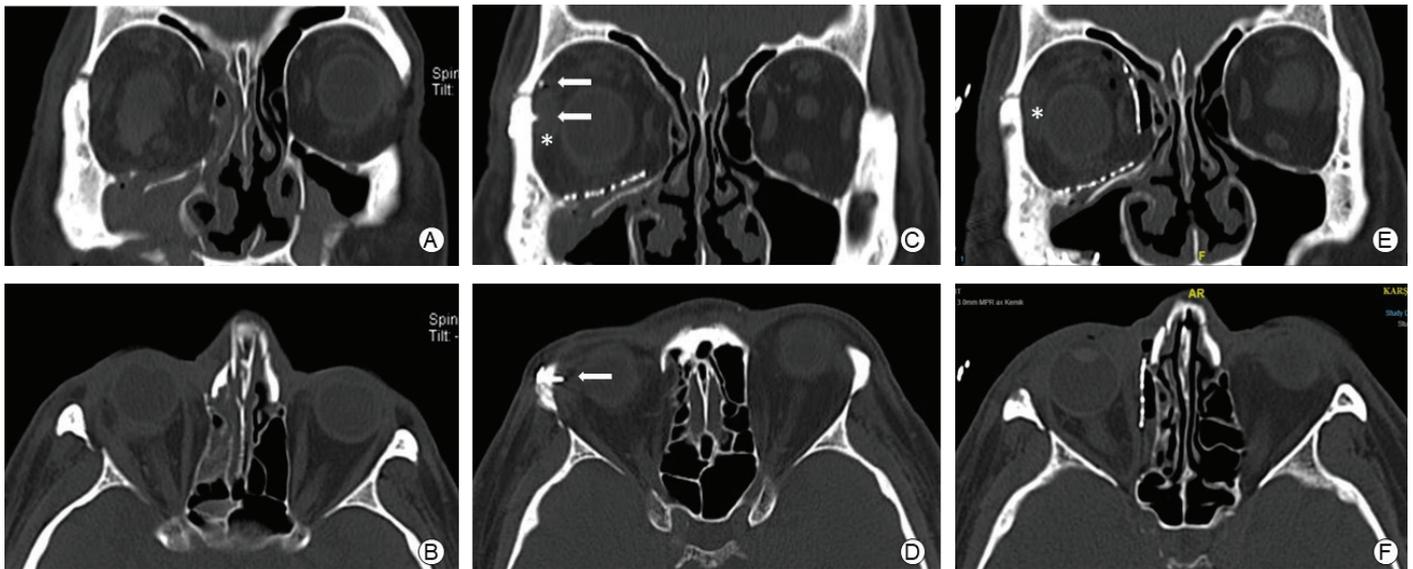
A, B: Post traumatic, C,D: Preoperative, E,F: Postoperative CT images; white arrow: screws, asterix: lateral rectus muscle
